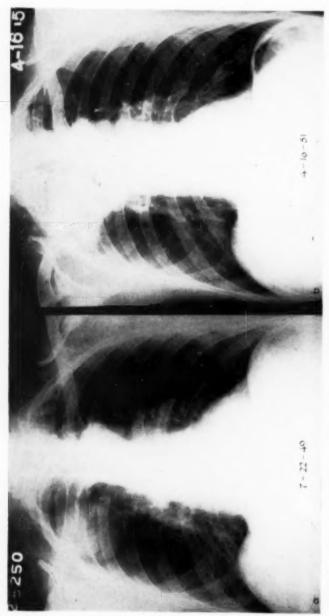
(Case 2); Carcinoma lung arising peripherally and extending into major bronchus. — (A) Mass in right upper lobe with poorly defined borders, peripheral origin, found during chest survey, no symptoms. - (B) Atelectasis right upper lobe from obstruction of bronchus. Symptoms began only one month before, 20 months after the first x-ray finding. The appearance here is characteristic of tumors arising in a major bronchus, yet the earlier film (A) indicates a peripheral origin.
